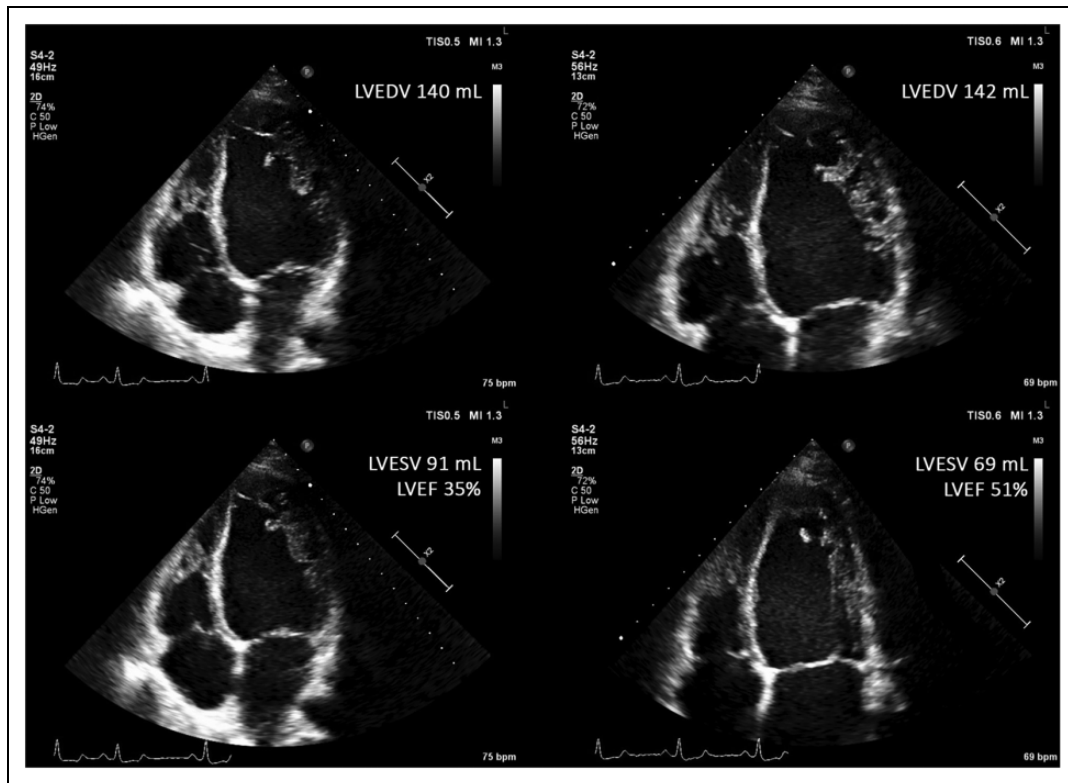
Echocardiography still images of our patient before (left hand side) and after (right hand side) CD34⁺ cell injection, showing improvement of LVEF from 35 to 51%.
